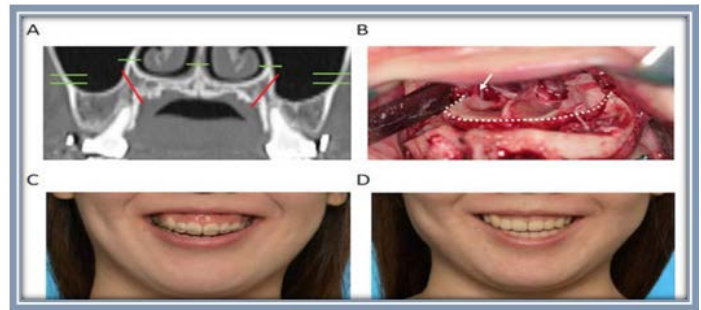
Patient being treated for a gummy smile. A: CT image at the molar region. Osteotomy lines shows Le Fort I (green) and horseshoe (red). B: perioperative photograph of horseshoe osteotomy. C and D: frontal view pictures of preoperative and postoperative full smile. Dotted line, osteotomy line; arrow, descending palatine arter
